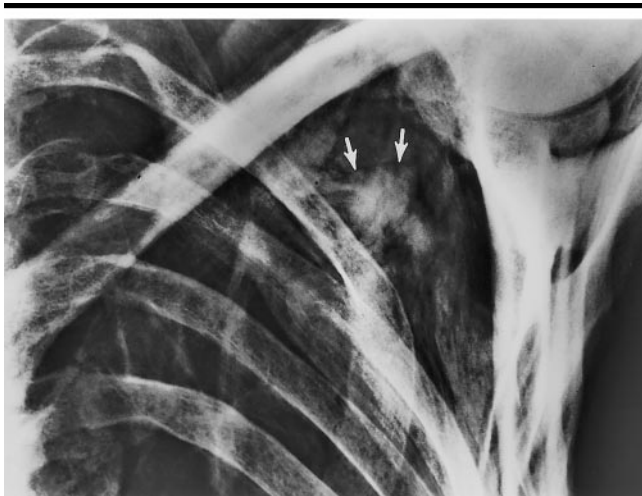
Irregular opacity (arrows) in the left shoulder retrospectively detected on a conventional frontal radiograph of the chest (obtained on September 26, 1991) has the general configuration of an arrowhead. Also in retrospect, the arrowhead is visible on the radiograph obtained on May 25, 1993 (Fig 8).
